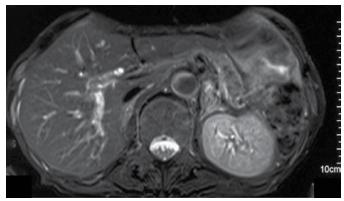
Magnetic resonance imaging scan two years after distal gastrectomy. T2-weighted MRI scan showed the existence of the tumor in the pancreatic body, and the tumor seemed to infiltrate into the main pancreatic duct.
